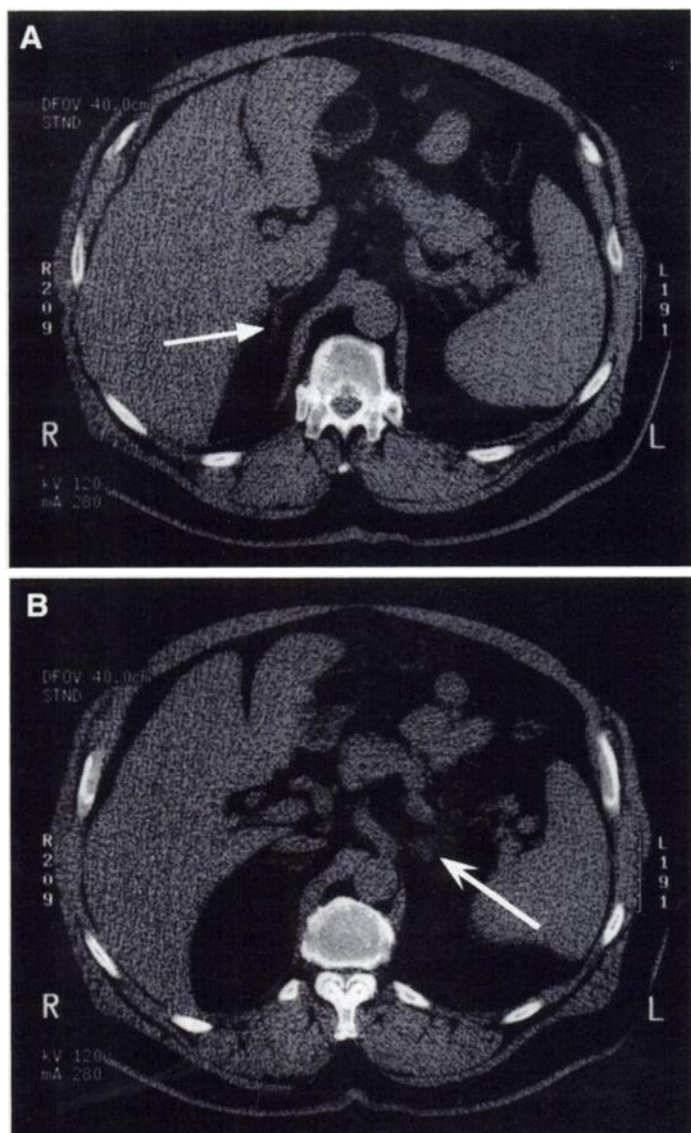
(A) Noncontrast transaxial CT slice shows normal right adrenal gland (arrow). (B) Adjacent transaxial slice shows lobulated left adrenal gland (arrow) measuring 2×3 cm with areas of low attenuation (7.1 H), consistent with an adenoma. In addition, the inferior pole of the left kidney contained a large cystic lesion (not shown).
